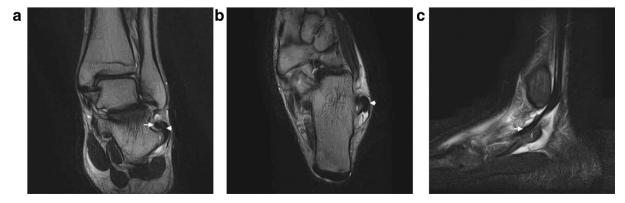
Coronal (A), axial (B) and sagittal (C) T2-weighted magnetic resonance images: the peroneus brevis tendon (arrow) is in its anatomical place over the peroneal tubercle (§), while the peroneus longus tendon (PLT, arrowhead) is dislocated superiorly and anteriorly; concomitant tenosynovitis of the PLT is present.
